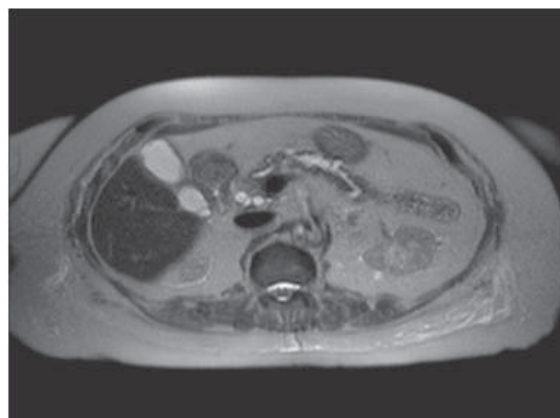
Magnetic resonance imaging of the pancreas showing multiple loculated lesions suggestive of intraductal papillary mucinous neoplasms.
